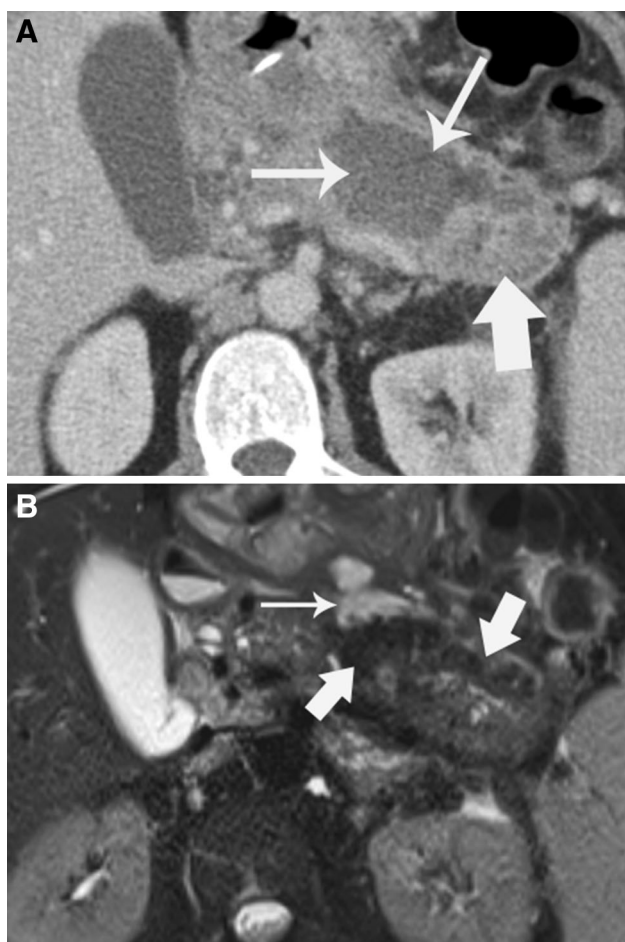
49-year-old man with severe necrotizing pancreatitis. A Axial contrast-enhanced CT image obtained shows a large peri-pancreatic collection (*arrow*) with apparently a large amount of fluid. The average density of the collection was 28.44 ± 18.2 HU. B Axial T2-weighted MRI image at the same level obtained two days later demonstrates large areas of debris (*thick arrows*) and only a small pocket of fluid (*thin arrow*).
